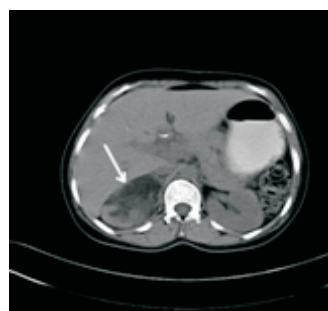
Axial plain CT scan image showing a mass in the right supra renal region containing low attenuation areas consistent with myelolipoma.
